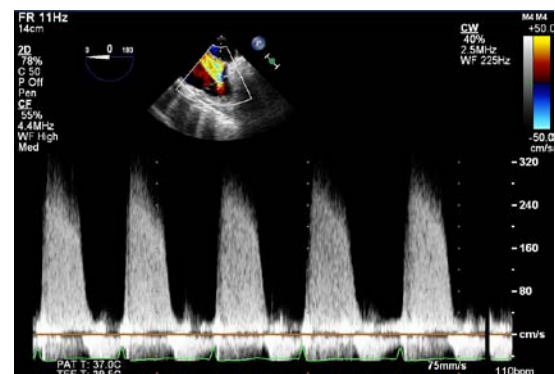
Severe tricuspid regurgitation on continuous wave Doppler (103)
